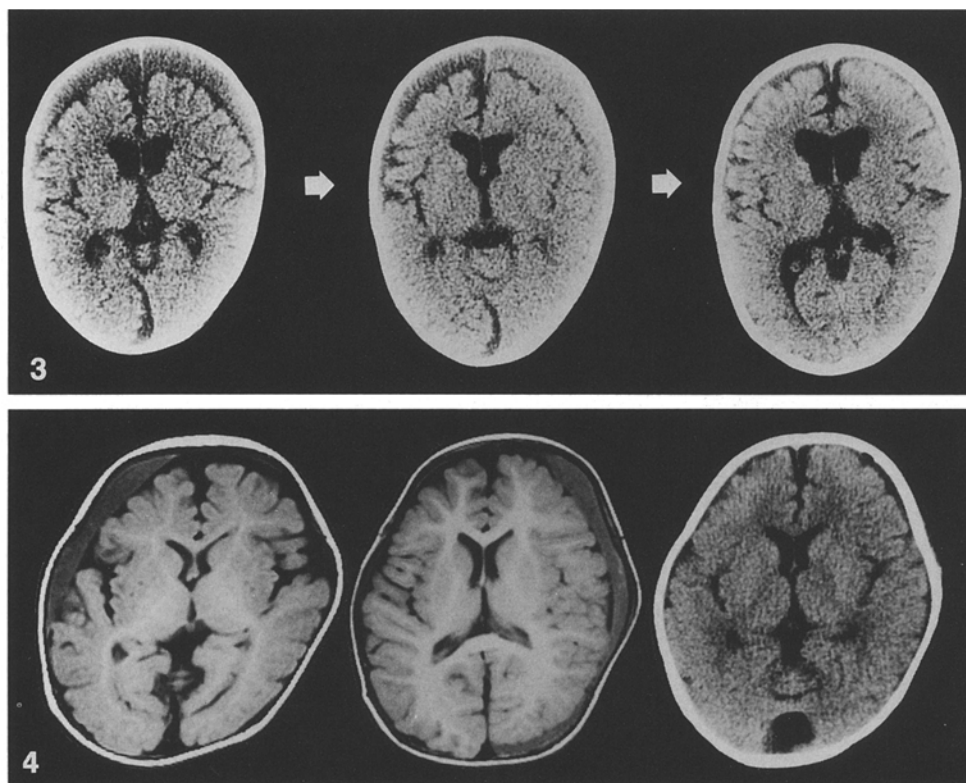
CT scans showing a subdural hematoma induced by repeated subdural taps in a 6-month-old male infant with infantile subarachnoid fluid collection. *Left:* CT scan at 7 months of age shows infantile subarachnoid fluid collection. *Middle:* CT scan after repeated subdural taps shows a subdural hematoma on the left side. *Right:* CT scan at 11 months of age after subdural-peritoneal shunt shows an improvement of the subdural hematoma and subarachnoid fluid collection
